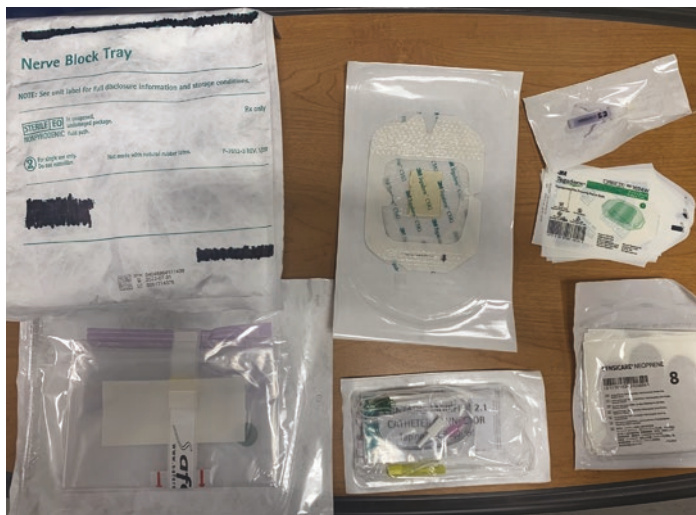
CPNB supplies: (Upper left counterclockwise) PNB tray (sterile drape, syringes, etc...), chloroprep impregnated tegaderm, dermabond sealant, small tegaderm, sterile gloves, CPNB needle kit with catheter, sterile ultrasound cover
